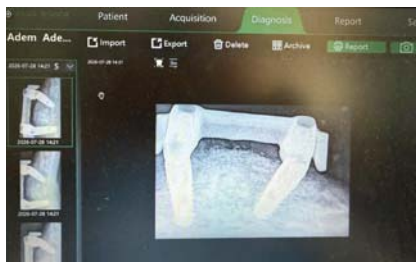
Post-treatment periapical radiograph obtained following completion of HELBO® antimicrobial photodynamic therapy, demonstrating stable implant positioning with no radiographic evidence of peri-implant bone loss or other pathological changes.
